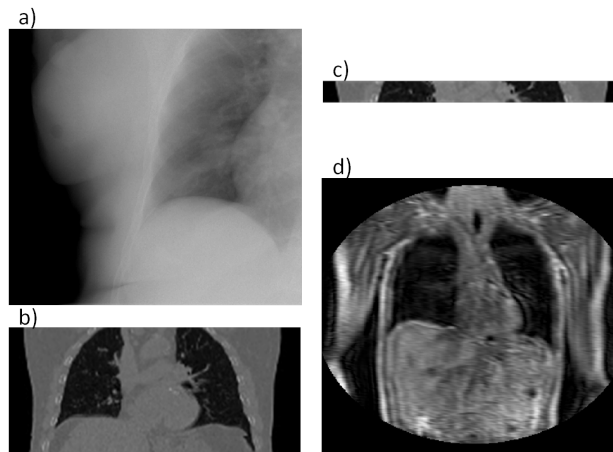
Examples of the different types of imaging data that have been used to image the respiratory motion of the internal anatomy. a) An x-ray projection image, b) a 4DCT volume, c) A Cine CT volume, d) A dynamic MRI volume (acquisition time approx 250 ms for the full volume).
